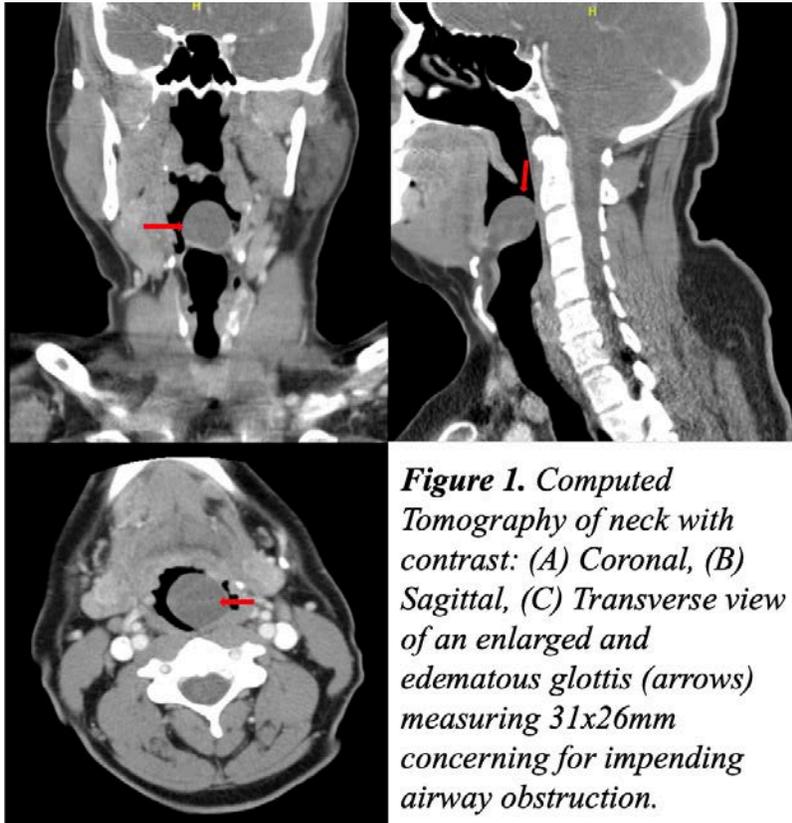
Computed Tomography of neck with contrast: (A) Coronal, (B) Sagittal, (C) Transverse view of an enlarged and edematous glottis (arrows) measuring 31x26mm concerning for impending airway obstruction.*
